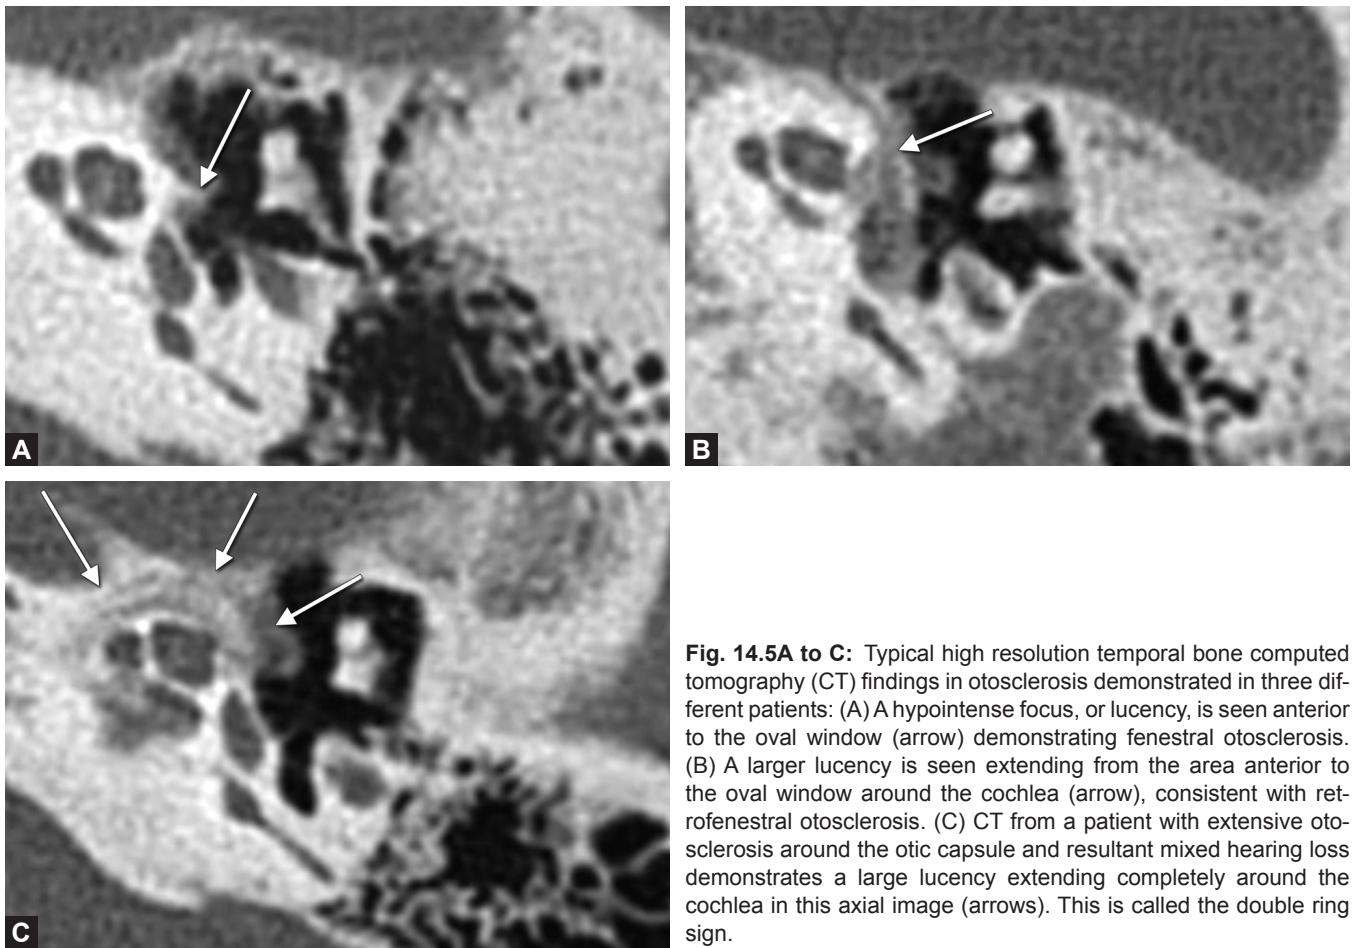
to C: Typical high resolution temporal bone computed tomography (CT) findings in otosclerosis demonstrated in three different patients: (A) A hypointense focus, or lucency, is seen anterior to the oval window (arrow) demonstrating fenestral otosclerosis. (B) A larger lucency is seen extending from the area anterior to the oval window around the cochlea (arrow), consistent with retrofenestral otosclerosis. (C) CT from a patient with extensive otosclerosis around the otic capsule and resultant mixed hearing loss demonstrates a large lucency extending completely around the cochlea in this axial image (arrows). This is called the double ring sign.
